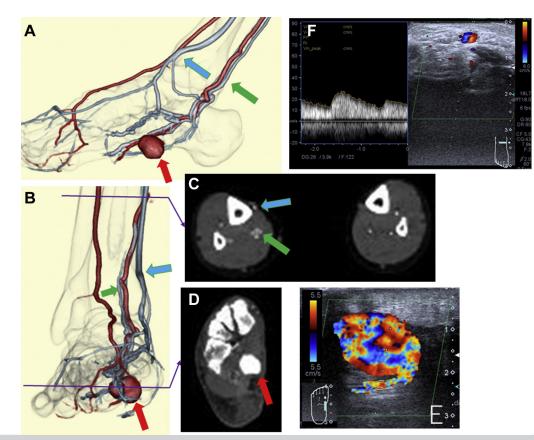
Computed tomography and ultrasound images on day 30 after the injury. *Red arrow*, pseudoaneurysm. *Green arrow*, early venous return to the posterior tibial vein. *Blue arrow*, early venous return to great saphenous vein. A, Volume-rendered lateral view of the right foot. B, Volume-rendered frontal view of the right foot. C, Axial view of the right lower leg. D, Axial view of the right foot and the pseudoaneurysm. E, Color Doppler image of great saphenous vein at the ankle that reveals arterial flow in the great saphenous vein.
